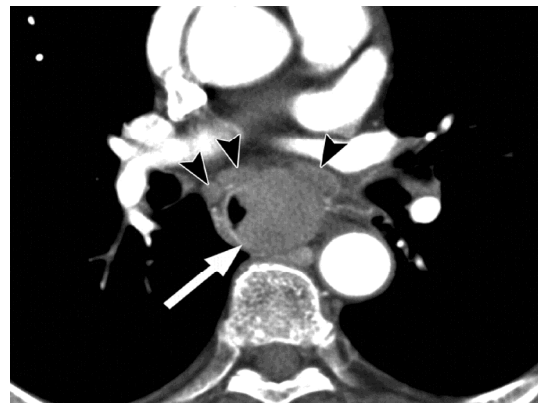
Computed tomography – large mid oesophageal lesion at the level of the mid-oesophagus with multiple large metastatic lymph nodes
